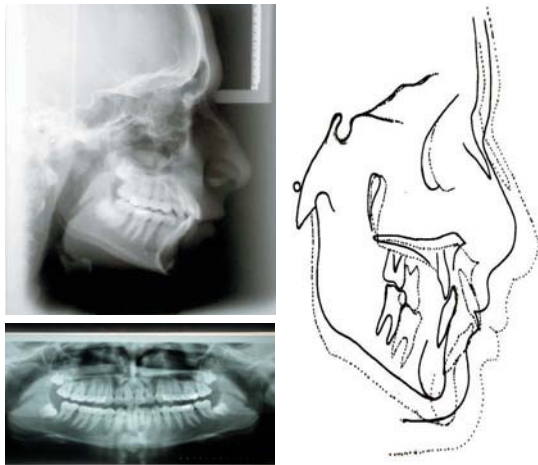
Two years post-treatment radiographs and cephalometric superimposition.
